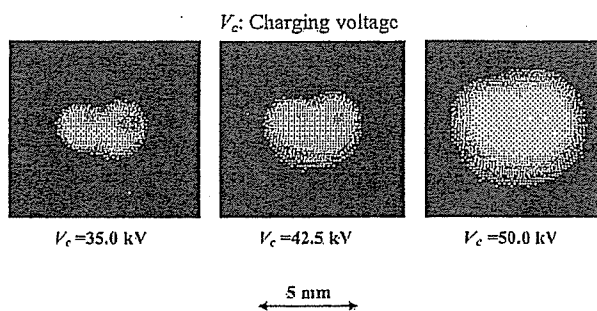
Images of plasma x-ray source of double target.
